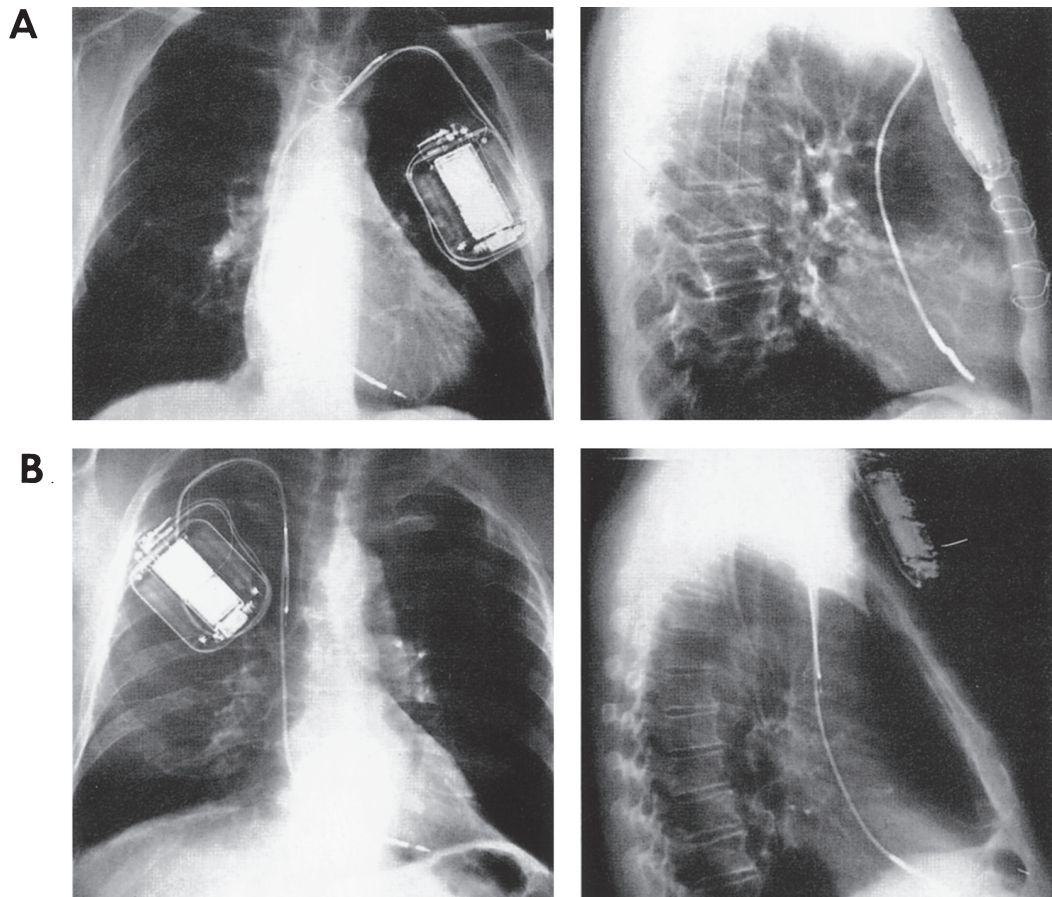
Chest radiographs depict active pulse generator shell system with an added proximal defibrillation coil to optimize defibrillation threshold.
